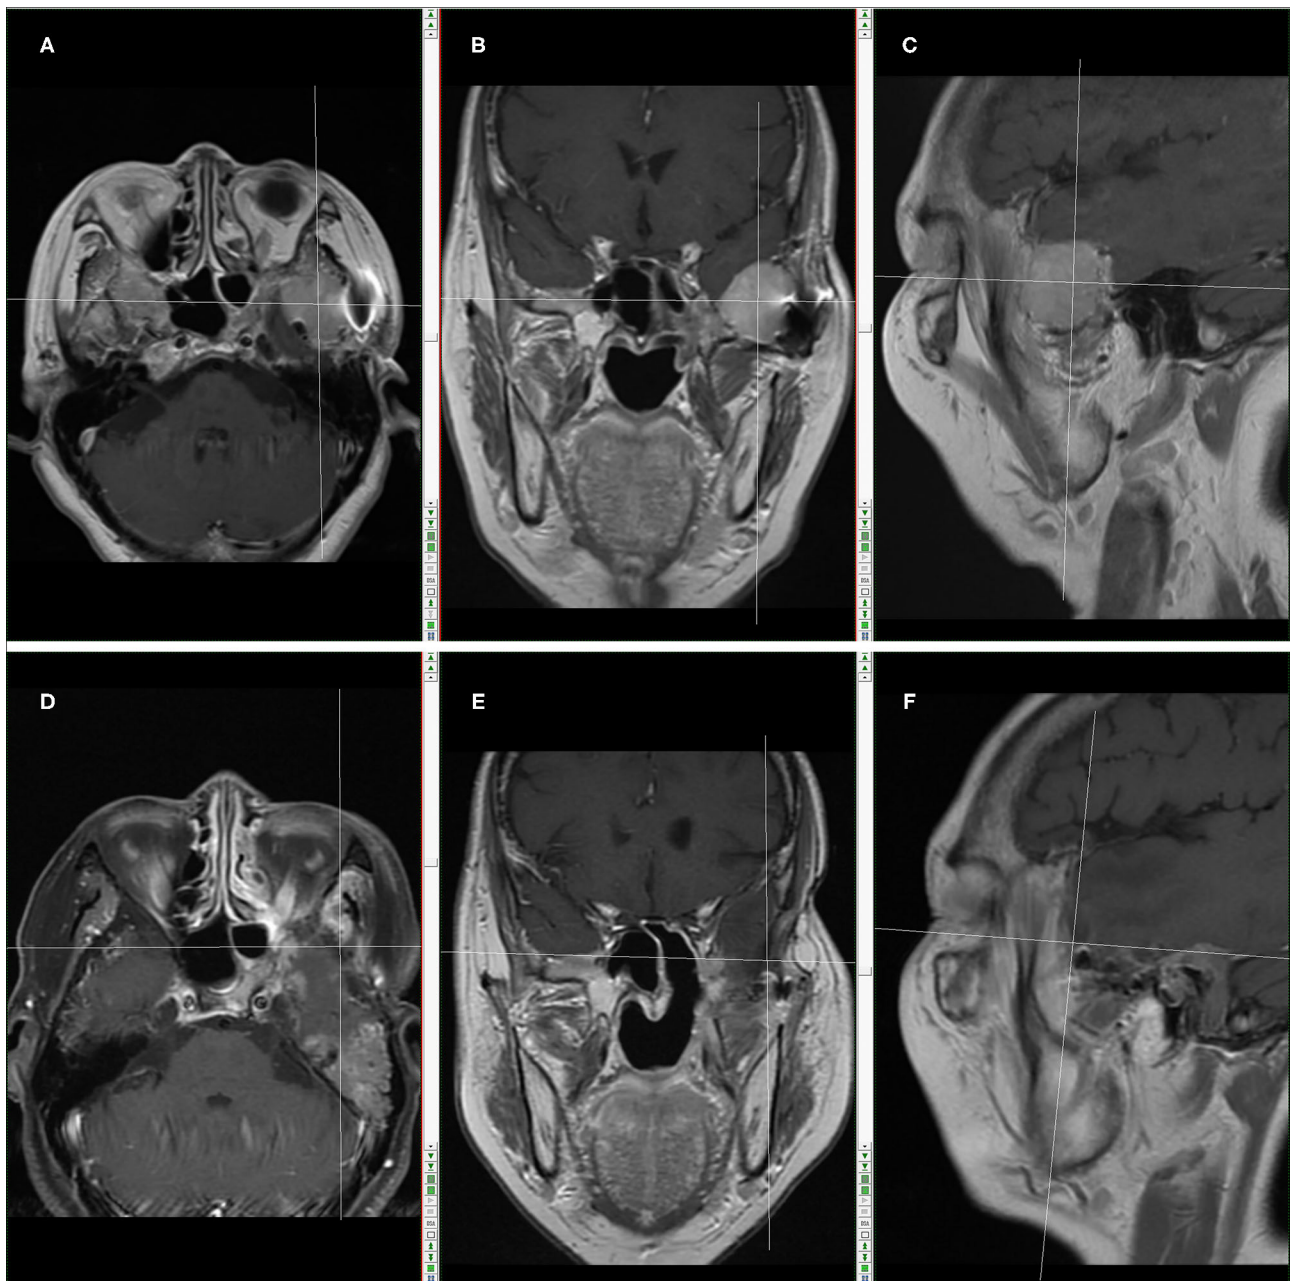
Skull base MRI in May, 2018 (Before the operation combined with carbon-ion radiotherapy): (A) MR images in transection. (B) MR images in coronal plane; (C) MR images in sagittal plane. The cross location denotes the recurring tumor. Skull base MRI in March, 2019 (After the operation combined with carbon-ion radiotherapy): (D) MR images in transection; (E) MR images in coronal plane; (F) MR images in sagittal plane. The cross location denotes no recurrent tumor.
